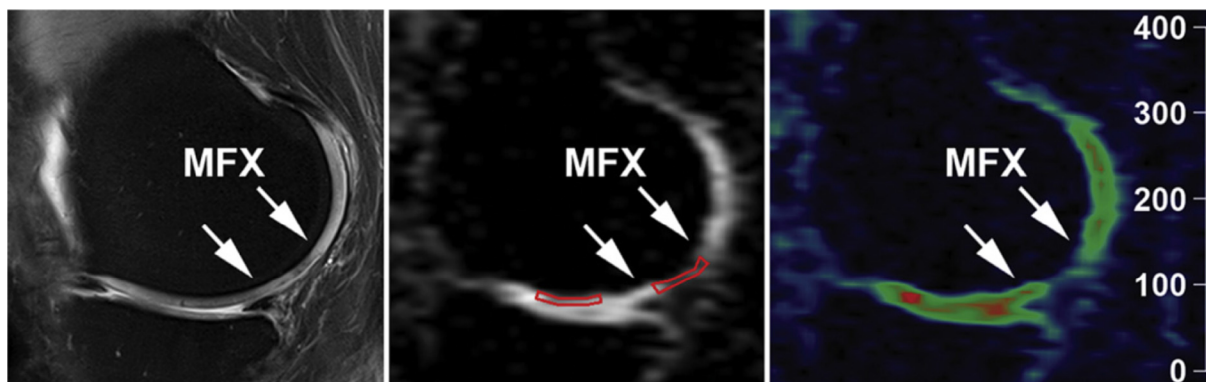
Sagittal proton-density-weighted 2D TSE MR image with fat suppression (left), sagittal sodium 3D GRE image (middle), and color-coded sagittal sodium 3D GRE image (right) in a 43-year-old woman obtained 42 months after a microfracture (MFX) procedure. Cartilage repair tissue is situated between the two arrows. Red contours in the middle image represent the ROI analysis of repair tissue (right contour) and reference cartilage (left contour). Color scale represents the sodium signal intensity values. Reproduced from [388]. With permission of Elsevier.
